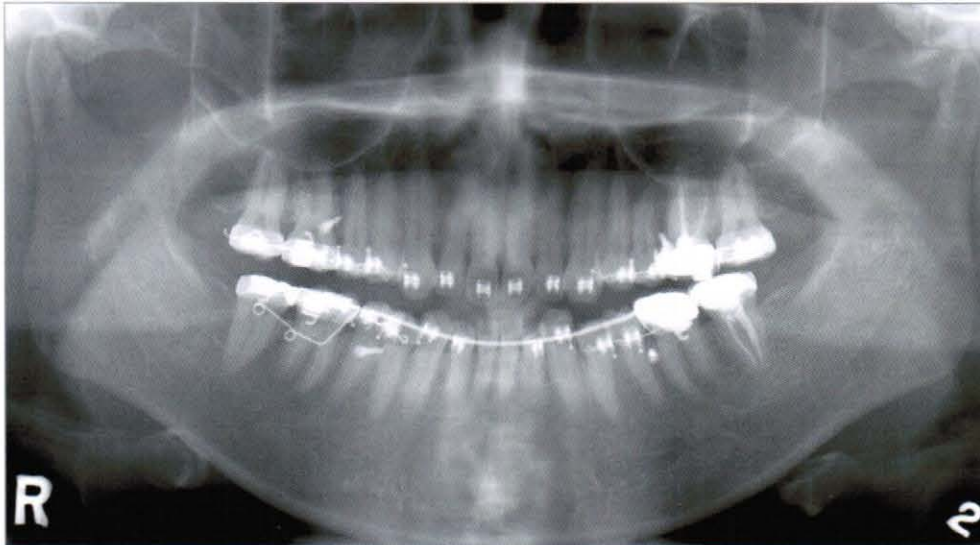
Panoramic radiograph taken during molar intrusion
